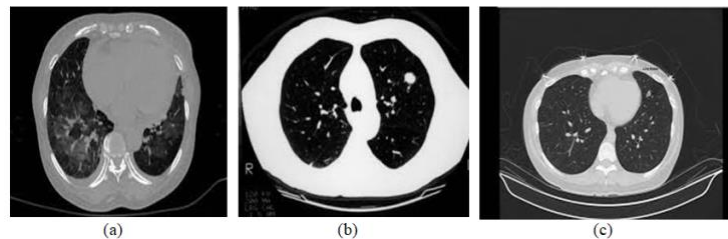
(a) CT-image with <3mm Lung Nodules (b) CT-image >3mm Lung Nodules (c) CT-image with Artificial Lung Nodules
